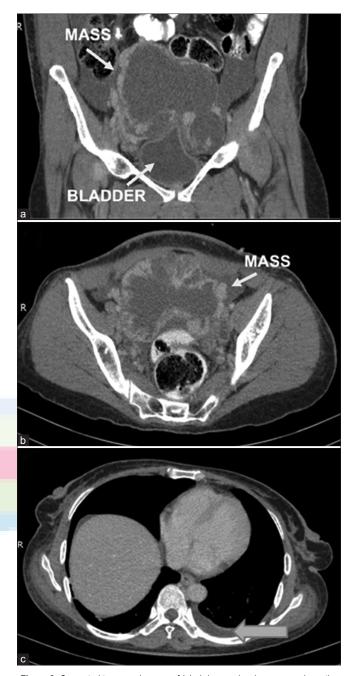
Computed tomography scan of (a) abdomen showing a mass above the urinary bladder and central in location, (b) abdomen showing the mass exhibiting variable thickening with enhancement at the walls and nonenhancing cystic appearing at the internal region, and (c) chest showing minimal left pleural effusion
